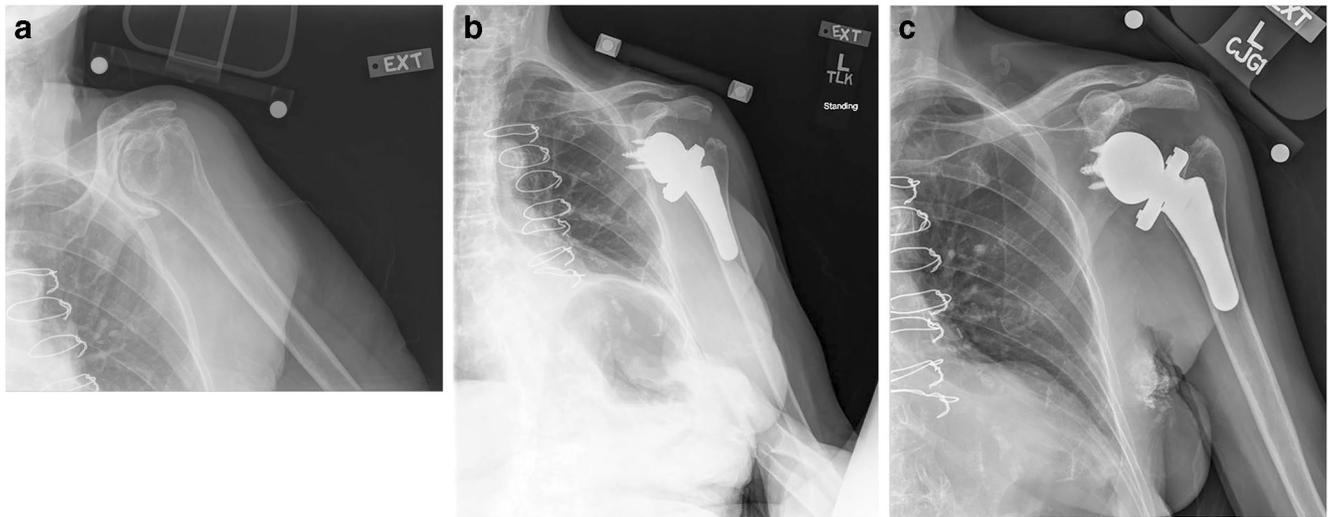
Challenging case: a Pre-operative, b Initial post-operative, and c Final follow up (27 months post-surgery) x-rays of an 83-year-old female with significant glenoid bone loss requiring structural bone grafting to the posterior glenoid taken from the humeral head
